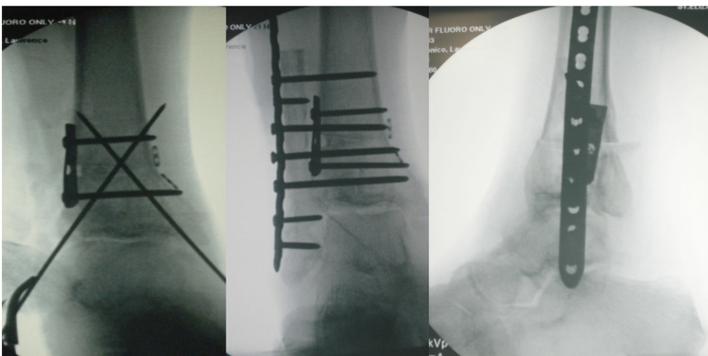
X-rays demonstrating fixation of the opening wedge osteotomy, fibular lengthening osteotomy, internal rotation of the distal fibula and syndesmotic fusion
